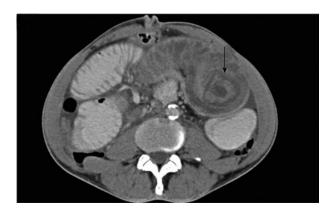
Computed tomography scan of the abdomen showing the intussusceptions of jejunum into the stomach via the gastrojejunostomy.
